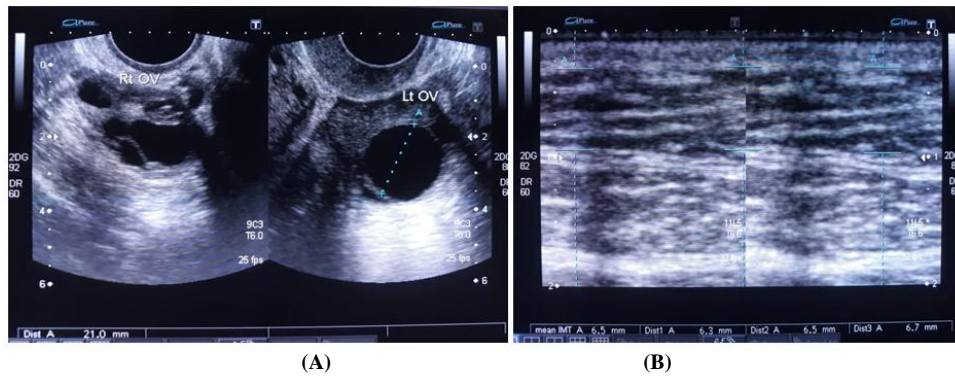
The transvaginal ultrasound image shows normal appearance of both ovaries, Left ovary shows a mature follicle of 20mm. The transabdominal ultrasound image shows subcutaneous fat thickness at suprapubic region. (Married, age 33years)
